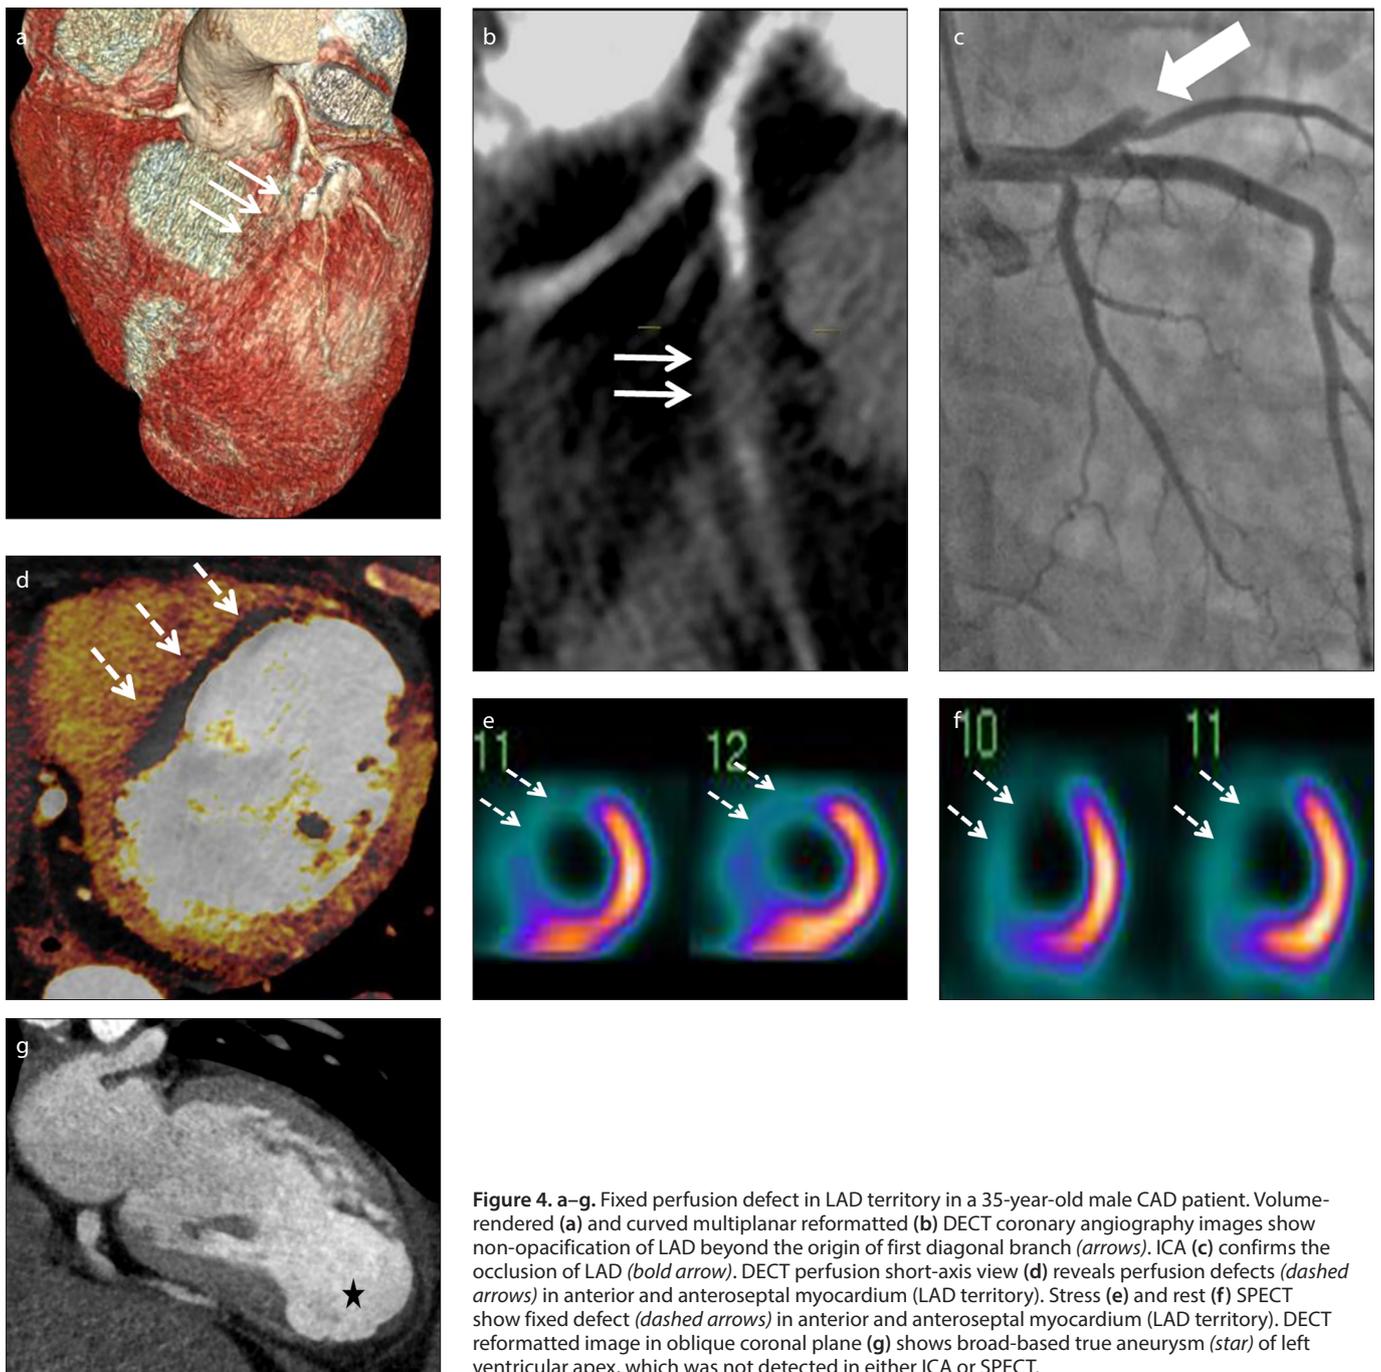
a–g. Fixed perfusion defect in LAD territory in a 35-year-old male CAD patient. Volume-rendered (a) and curved multiplanar reformatted (b) DECT coronary angiography images show non-opacification of LAD beyond the origin of first diagonal branch (arrows). ICA (c) confirms the occlusion of LAD (bold arrow). DECT perfusion short-axis view (d) reveals perfusion defects (dashed arrows) in anterior and anteroseptal myocardium (LAD territory). Stress (e) and rest (f) SPECT show fixed defect (dashed arrows) in anterior and anteroseptal myocardium (LAD territory). DECT reformatted image in oblique coronal plane (g) shows broad-based true aneurysm (star) of left ventricular apex, which was not detected in either ICA or SPECT.
